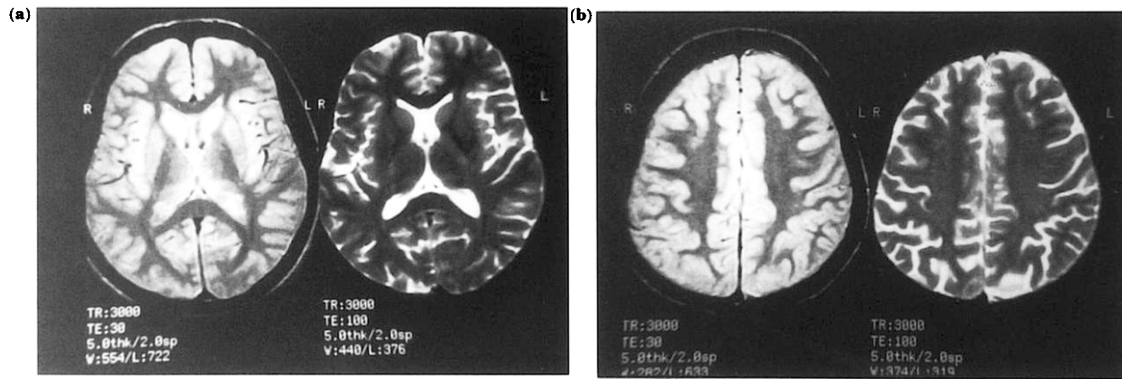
Repeated MRI scans done after a seizure and 24 months from her first seizure as a control scan revealed no pathologic signal intensities on both proton density (1.5T, TR 3000, TE 30) and T2-weighted (1.5T, TR 3000, TE 100) images at the level of the foramen Monro (a) and centrum semiovale (b).
